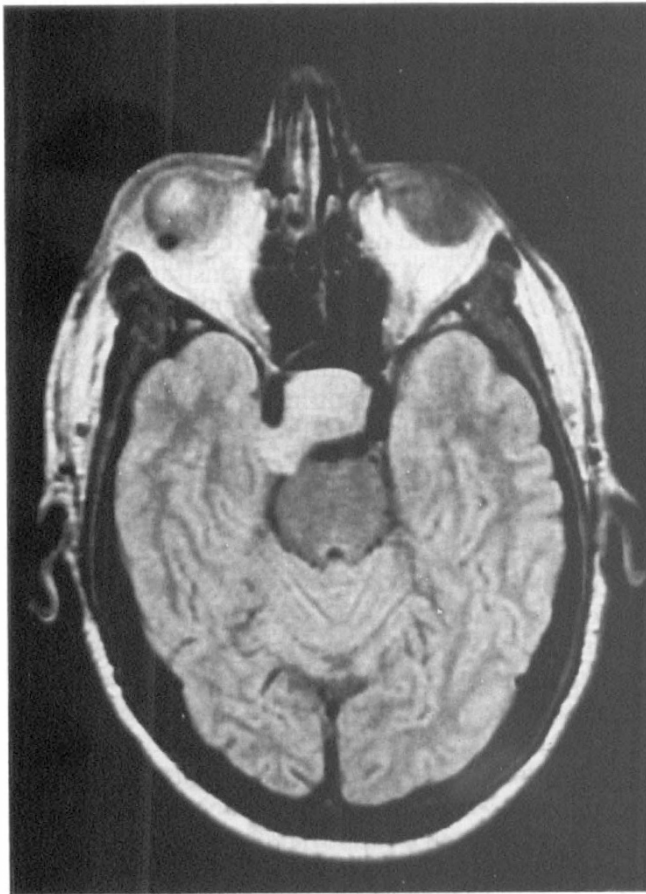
T1-weighted axial MRI scan with gadolinium contrast. There is invasion of the right cavernous sinus by a pituitary tumour which has taken up contrast. Note: the lateral end of the plomb is seen temporally next to the globe.
